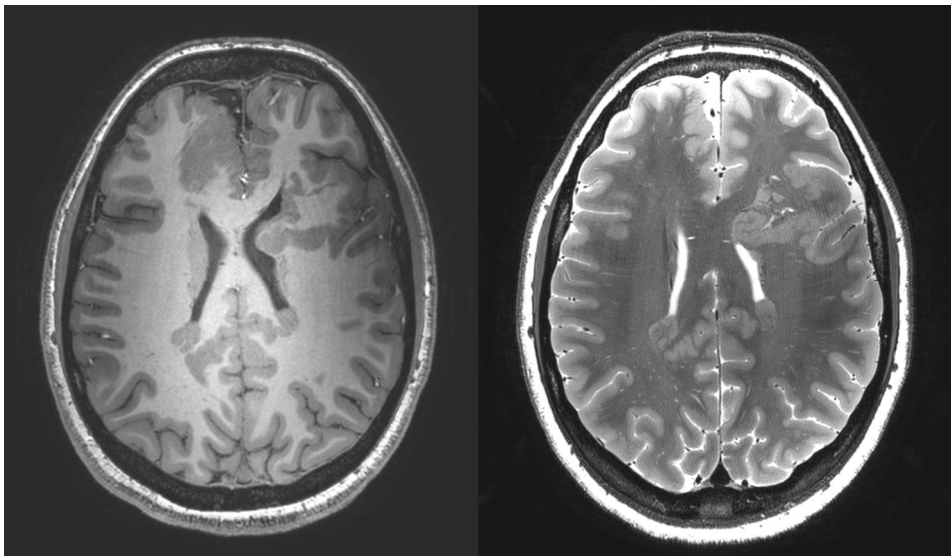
Axial T1-weighted (left) and T2-weighted (right) images acquired at 7T MRI demonstrate a subcortical heterotopia characterized by nodular gray matter located beneath the cortical mantle, with abnormal cortical morphology.
